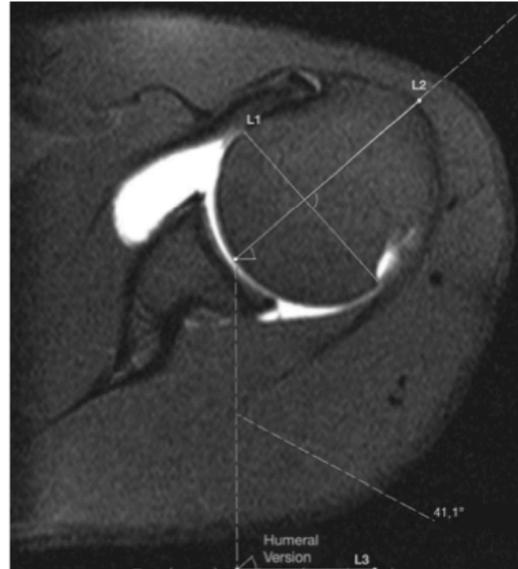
Humeral version, measured according to technique validated by Athwal et al,¹ using magnetic resonance imaging axial sections. The determined humeral version in this case was 41.1°. L1, line drawn between anterior and posterior limits of humeral head cartilage; L2, humeral head central axis, perpendicular to L1; L3, line parallel to magnetic resonance imaging scanner.
